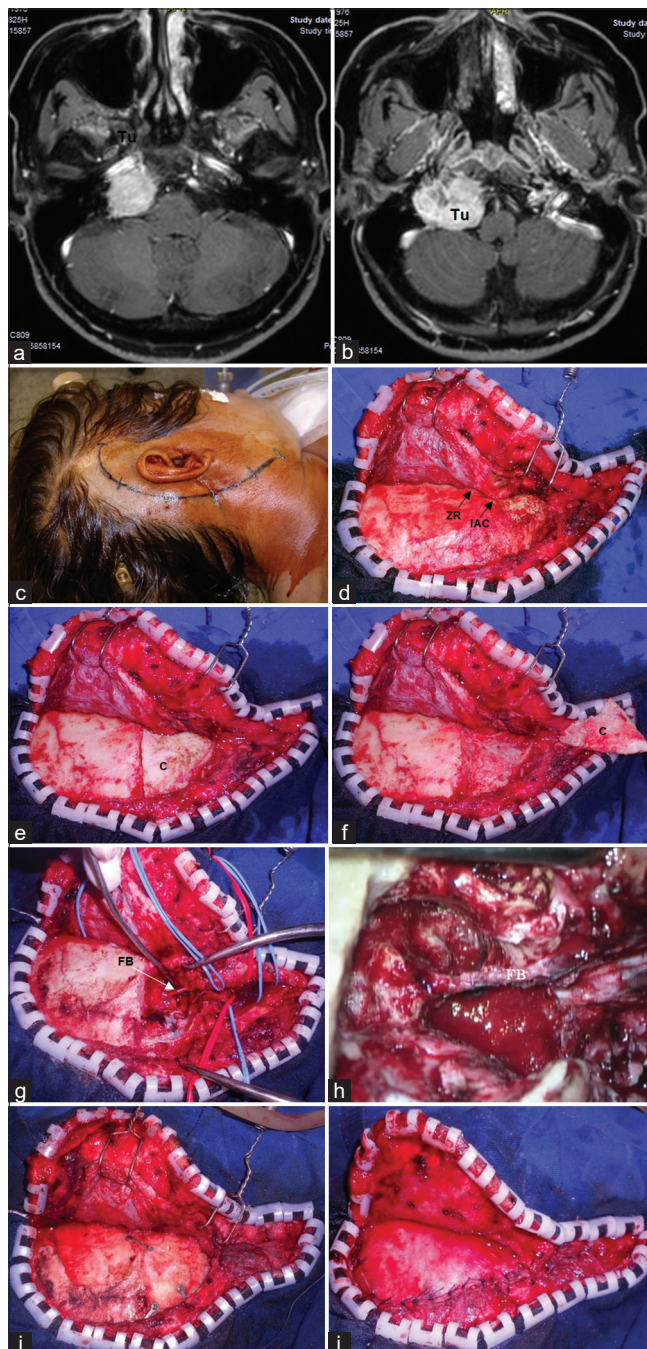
Steps for surgical approach of an infratemporal (IFTA-B) and cervical approach of a paraganglioma of the jugular foramen (JF) C3. (a and b) Preoperative axial T1-weighted contrast-enhanced MR images showing a large mass (Tu) located in the JF with extension to the cervical region and posterior fossa, pushing the dura-mater. (c) Skin incision. (d) Exposure of the temporal bone and mastoid process after anterior displacement of the skin and of the fascio/muscular (temporal and sternocleidomastoid muscles) flaps. (e) Cortical bone of the mastoid (c) separated and keep in place. (f) Cortical bone (c) of the mastoid displaced. (g) Mastoidectomy with a fallopian bridge (FB) and cervical exposure. (h) Magnification of the fallopian bridge (FP) after bone removal. (i) Cortical of the mastoid replaced and fixed with mini-plates and screws. (j) Suture of the fascio-muscular plane.
